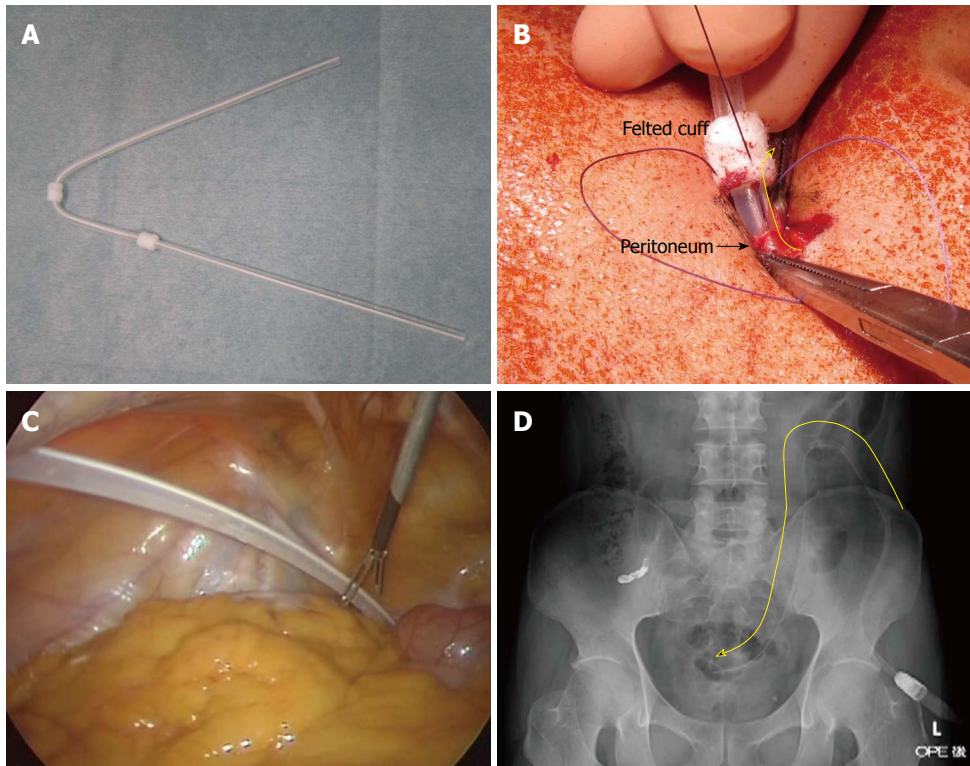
Actual material and surgical procedures. A: Double-felted swan-neck silicone catheter; B: Tube fixation to peritoneum. Peritoneum was reflected enough to make a secure fixation. A tight running suture was placed between the peritoneum and the felt cuff (yellow arrow); C: Laparoscopic view for tube placement. The catheter has been adequately directed by the fixation to the abdominal wall. The laparoscopic view confirmed that the catheter led to the rectovesical pouch; D: Intra-operative radiograph. Optimal and reasonable curve of catheter without any distortions was confirmed (yellow arrow).
